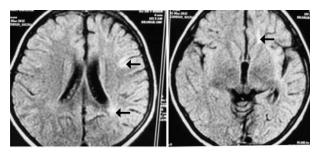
Brain MRI showing progressive left cerebral atrophy and ill-defined patchy T2 hyperintensities in left hemisphere in second patient.
